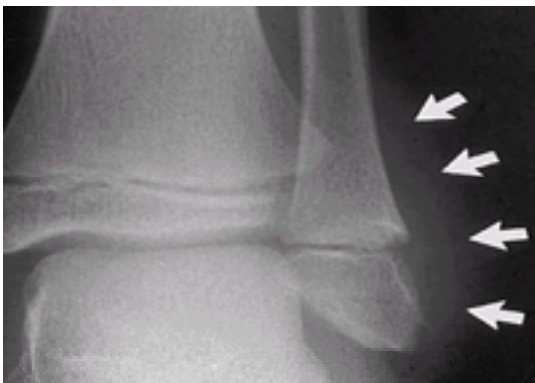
Radiograph of the left ankle of a 10-year-old boy notable only for soft-tissue swelling localized to the distal fibula (*arrows*). The presumptive diagnosis must be a Salter-Harris type I injury of the fibula.
